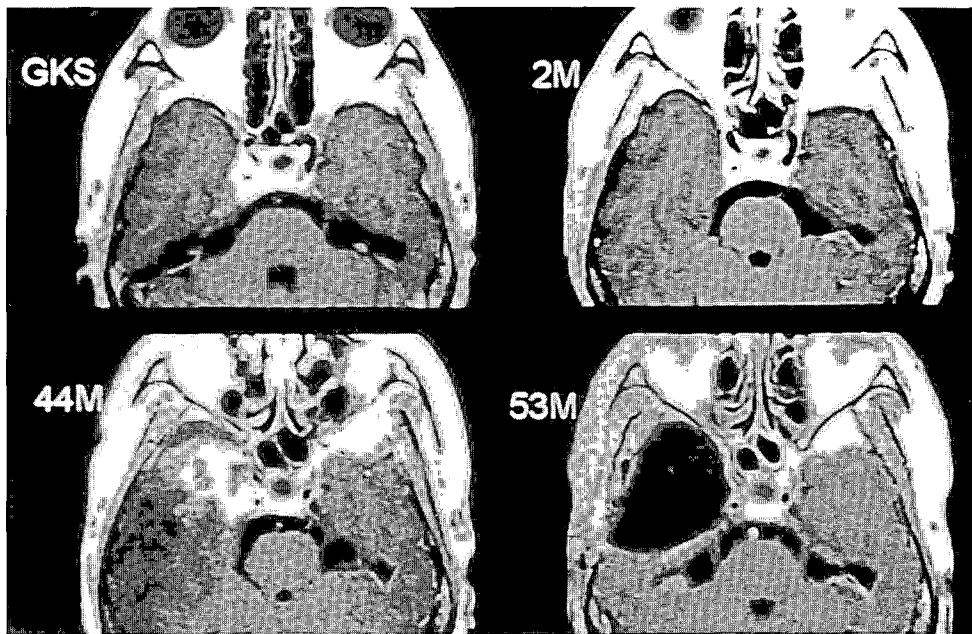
Long-term MRI follow-up of patient No. 3 (axial view). She had temporal lobectomy after right temporal lobe necrosis.
